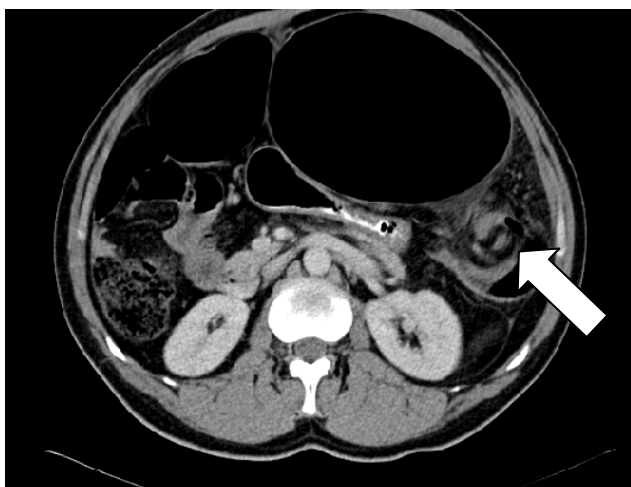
CT image showing dilated splenic flexure with whirl sign (arrow)
